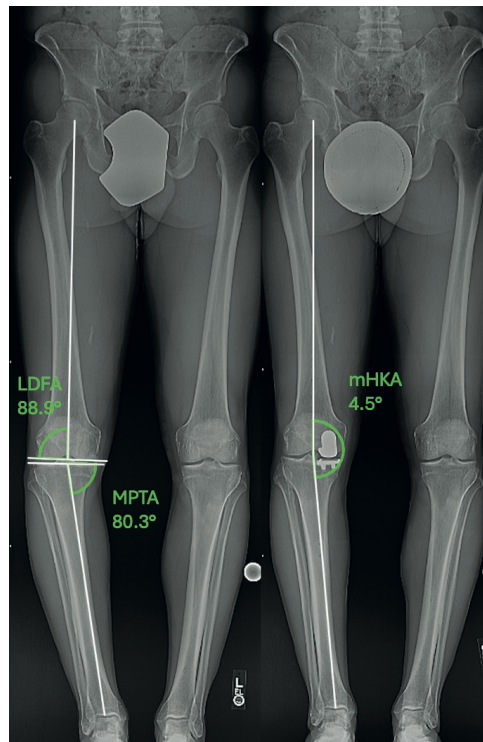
Long-leg radiograph of a patient with isolated anteromedial osteoarthritis both preoperatively and following medial UKA. LDFA, lateral distal femoral angle; mHKA; mechanical hip-knee-ankle angle; MPTA; medial proximal tibial angle; UKA, Unicompartmental knee arthroplasty.
